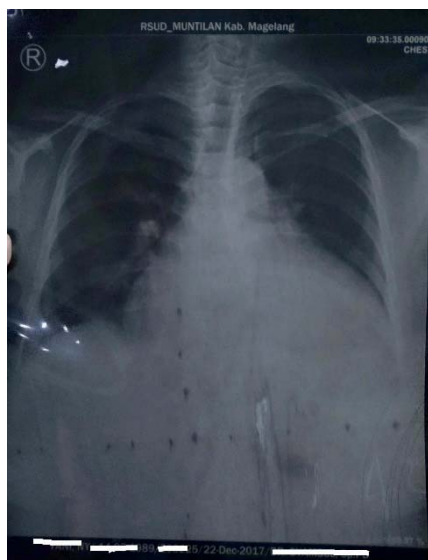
Chest Radiograph finding on the patient
